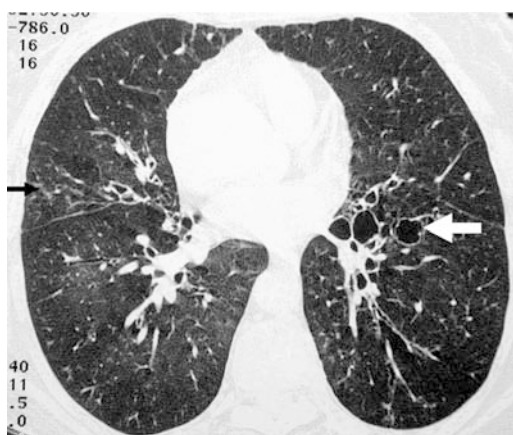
Chest HRCT of a 66-year-old woman (5 years' disease duration) demonstrating interstitial lung disease with interfaces irregularities, micronodules, parenchymal bands (*black arrow*) and severe bronchiectasis (*white arrow*)
